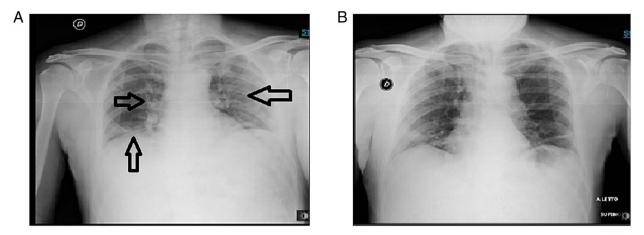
Chest X-ray results of the first patient in the present case series at (A) the time of admission and (B) upon improvement/discharge. Arrows indicate pathogenic lesions.
